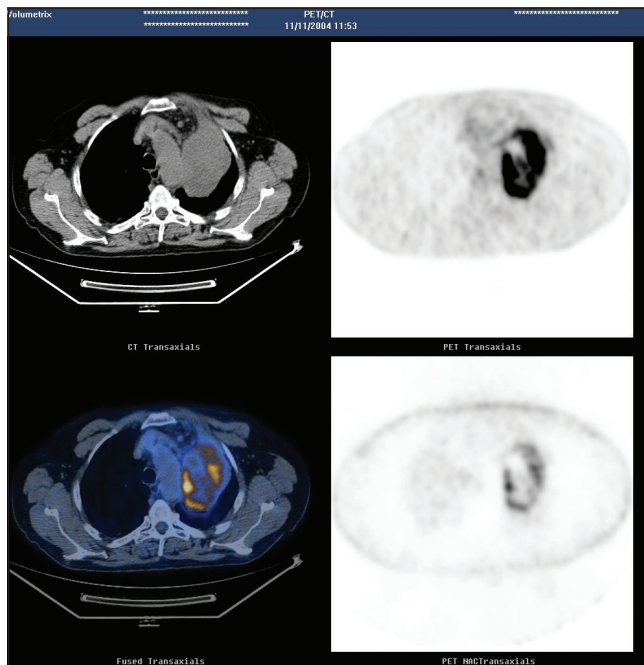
Transaxial image showing tumour with plane of cleavage from arch of aorta. Small volume of pre-vascular/superior mediastinal nodes on CT are not FDG avid.
